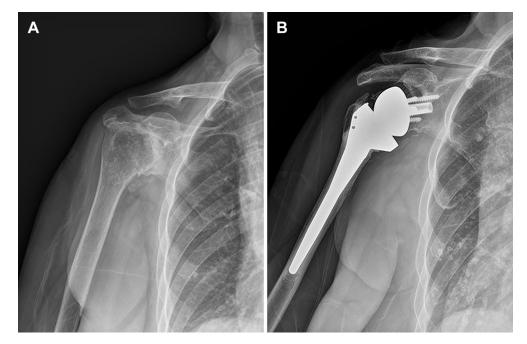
(A) Preoperative radiograph of a 61-year-old patient with rheumatoid arthritis showing medialization of glenohumeral joint caused by glenoid erosion. (B) Postoperative radiograph taken 34 months after bony increased-offset reverse shoulder arthroplasty.
